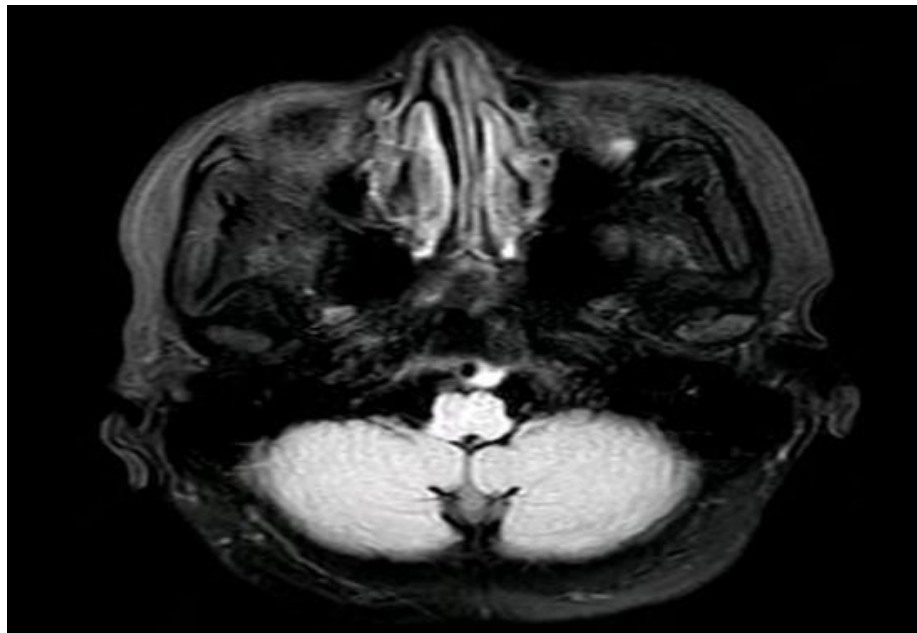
Brain MRI of a patient with SCA5 suggested demyelinating changes in bilateral Hemi-oval centers. (d-T2weighted), Cervical (MRI) showed cervical reverse arch, instability, cervical vertebral hyperplasia, and degeneration; cervical 5-6 disc herniation (central type), compression of the same level dural sac, thickening of the ligamentum flavum (e-T2weighted)
